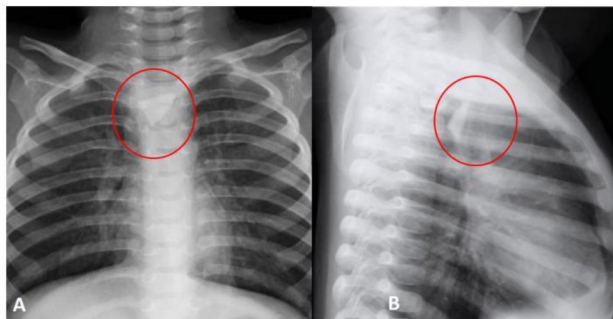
Plain Chest Radiograph. A. Anteroposterior view showing a triangular radiopaque object at the level of T1 and T2 B. Lateral view showing a triangular radiopaque object at the level of T1 and T2.
